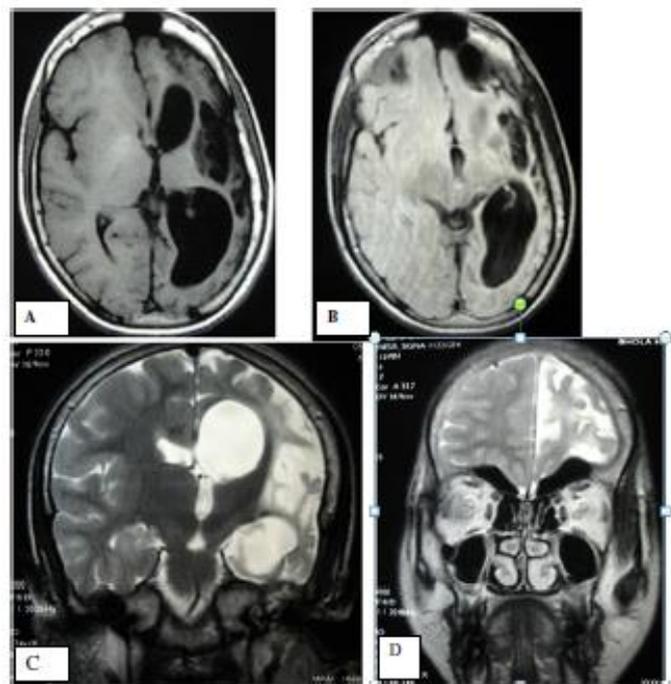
MRI different sequences A- Axial T1 weighted, B-Axial FLAIR, C-D Sagittal T2 weighted Images showing Dyke- Davidoff- Masson syndrome
